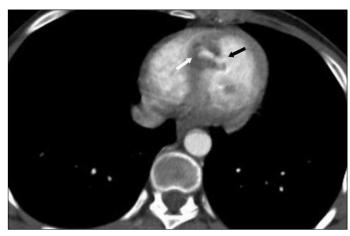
The thoracic CT axial image; a bilobular ruptured cystic lesion interventricular septum (white arrow) partially extending to the left ventricle (black arrow)
